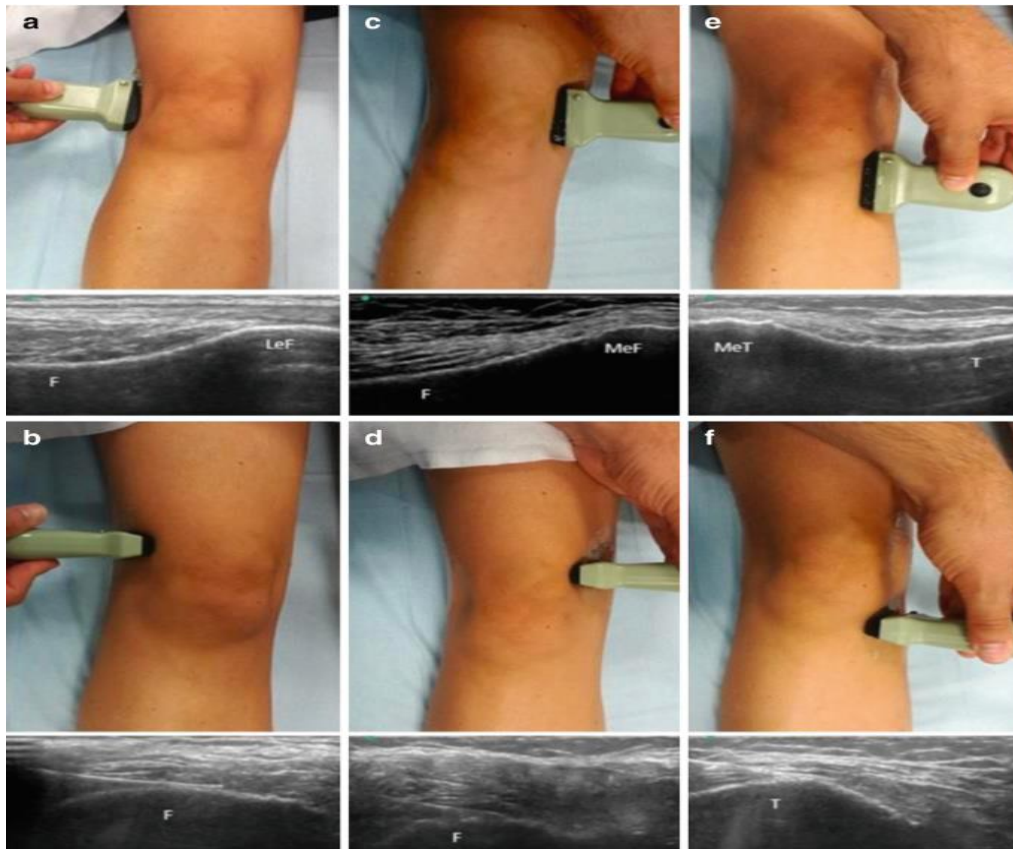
(a–c) putting the probe into a healthy volunteer and using the RF cannula to take precise ultrasound pictures of a cadaver. (a) The target position of the SLGN in the coronal plane. (b) The transverse plane is the ultimate location of the RF cannula for the SLGN. (c) The SMGN's is located in the coronal plane. (d) The SMGN's RF cannula is finally positioned in the transverse plane. (e) The IMGN's target location in the coronal plane. (f) The transverse plane is the ultimate location for the RF cannula of the IMGN. Right is distal (a, c, e), whereas left is proximal (a, c, e); Left means anterior, right means posterior (b, d, e). (Ghosh & Kohan, 2022).
